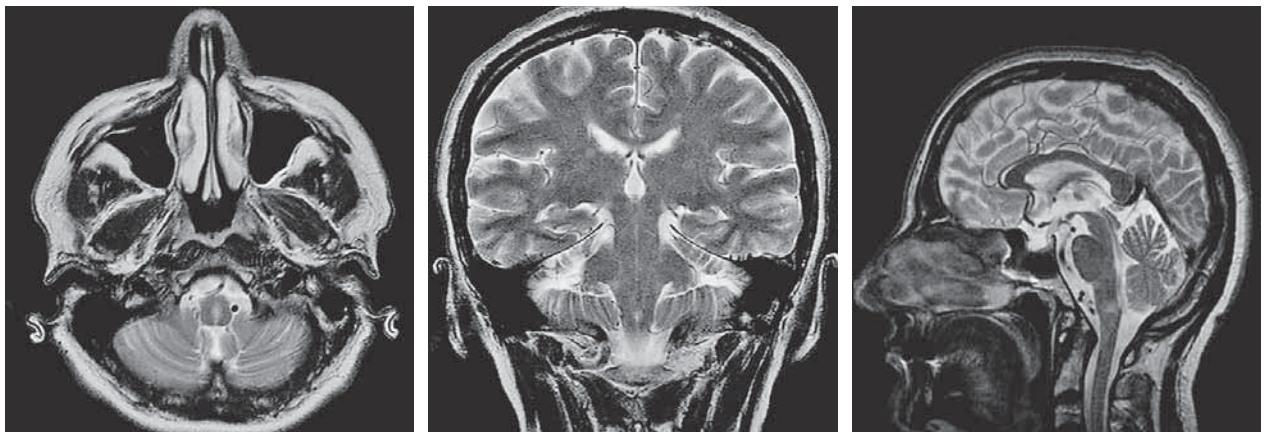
Brain MRI: (a) transverse, (b) coronal, and (c) sagittal sections showing demyelinating lesion in medulla oblongata.
